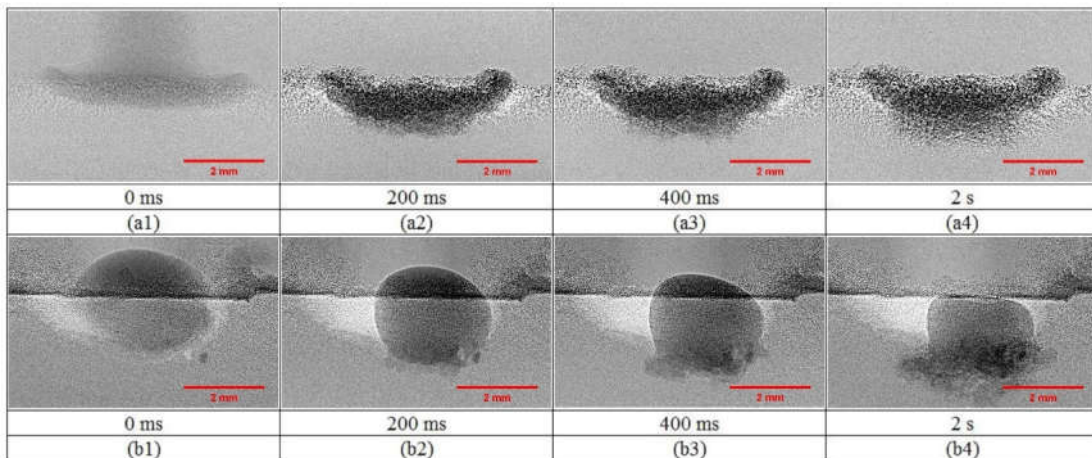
The time sequence X-ray images of the granulation process of MCC (a1-a4) and MCCF (b1-b4) powders with water as a liquid binder with 15 µl volume and 15 cm height.
